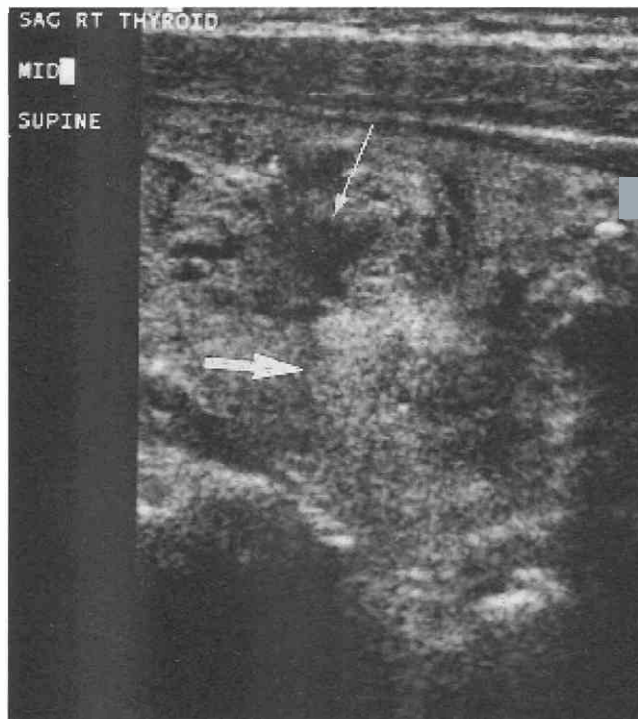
Multinodular goiter. Sagittal sonographic image of the right lobe of the thyroid reveals a heterogeneous, enlarged thyroid with predominantly hyperechoic (large arrow) but also hypoechoic (small arrow) nodules.
